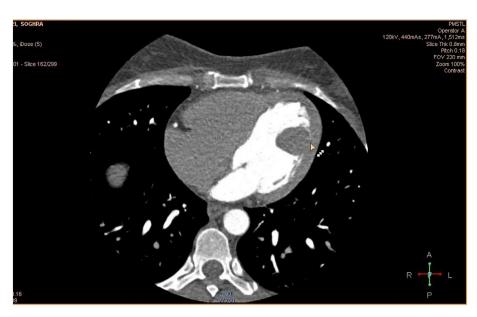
CT angiography showed a mass attached to the mid lateral wall of the LV.
